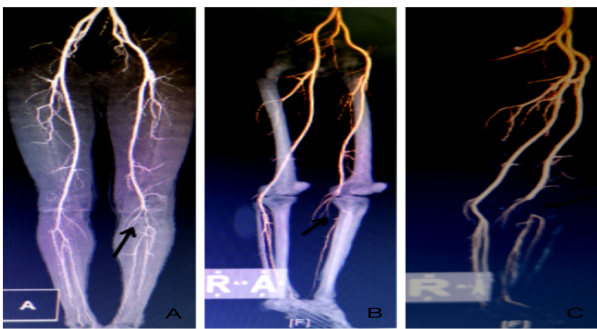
A, The front view of CTA before surgery. B, C, Lateral view of preoperative CTA. All showed local occlusion of the left popliteal artery. "→" indicating damage location.
